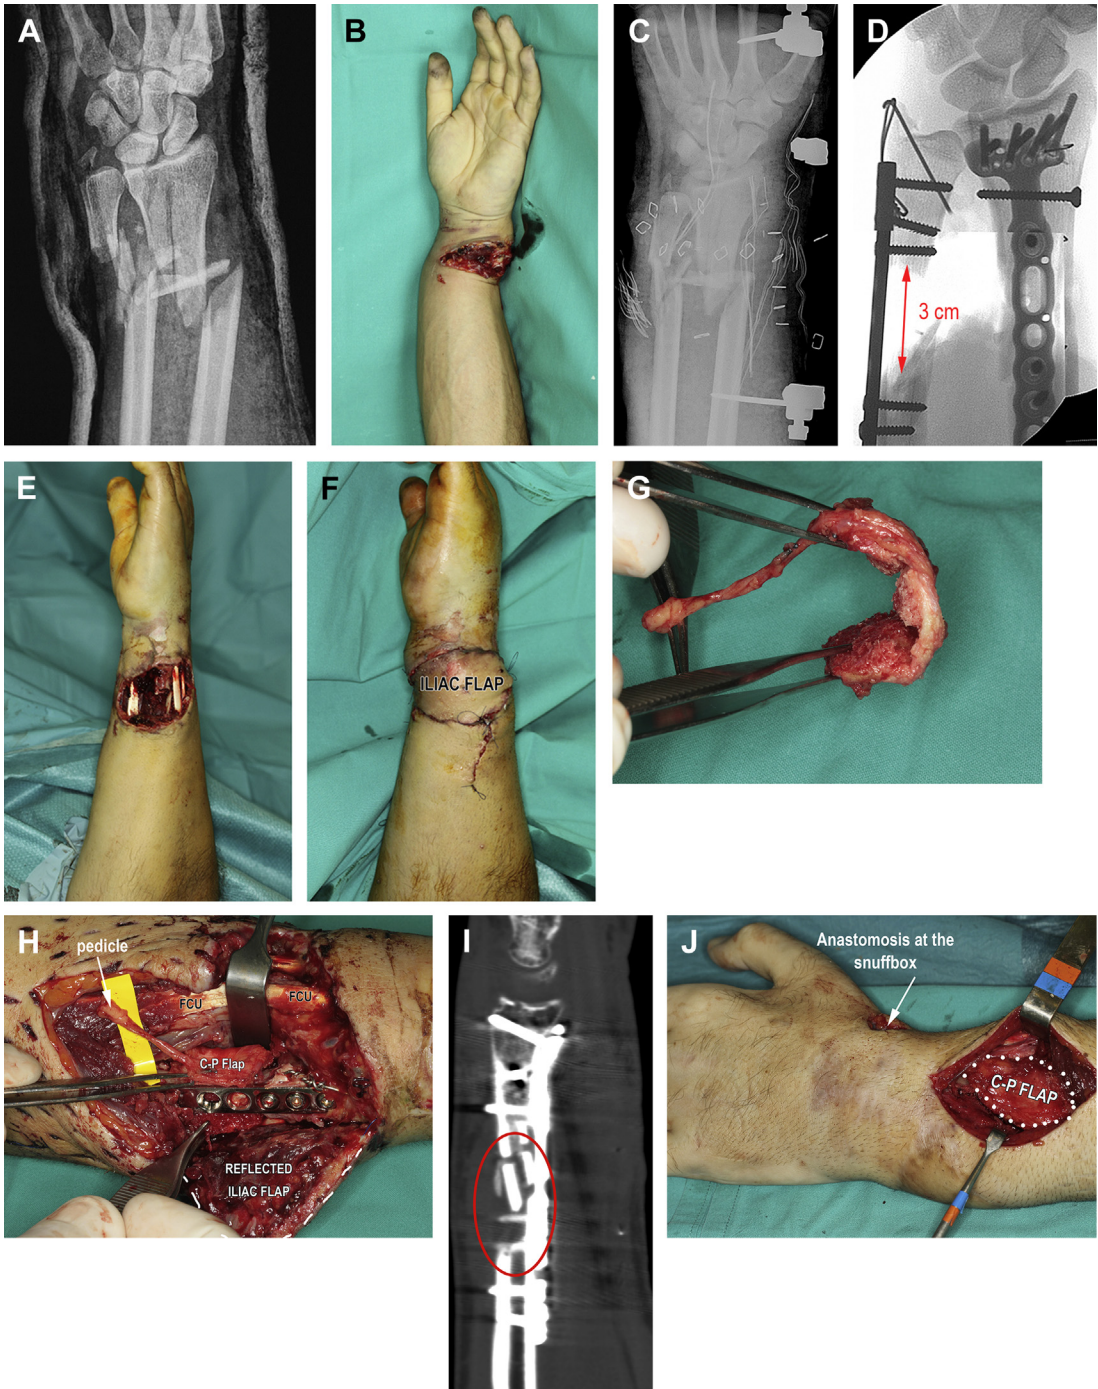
Multistage reconstruction. (A, B) Hand devascularization and corresponding initial radiographs. (C) Emergency double bypass at the wrist with vein grafts and repair of the tendons were performed. An external fixator temporarily maintained the reduction. (D–F) Three days later, the radius was arthroscopically reduced and fixed with the application of a plate, but the ulna was left with a gap of 3 cm. The ulnar soft tissue defect was covered with an iliac free flap. (G, H) On day 13, the iliac flap was elevated and reflected ulnarly. Notice the vascular repair was protected by the flexor carpi ulnaris. A medial femoral condyle corticoperiosteal flap (C-P flap) was tailored to wrap around the defect opposite the plate. (I) At 6 months, the patient reported a new pain in his radius. A computed tomographic scan revealed an evolving nonunion despite primary cancellous bone grafting. (J) The contralateral medial femoral condyle was used as a graft to treat a nonunion of the radius, and the 2.7-mm ulnar plate was removed concomitantly. (K, L) Result 9.5 months after the surgery. An artistic rendering of the surgery on this patient. (M) The patient felt so well that, without permission, he started going to the gym 2 months later. He is shown here doing pushups in the office 9.5 months after the original trauma. He regained full range of motion. (Copyright © 2015, Francisco del Piñal, MD.)
